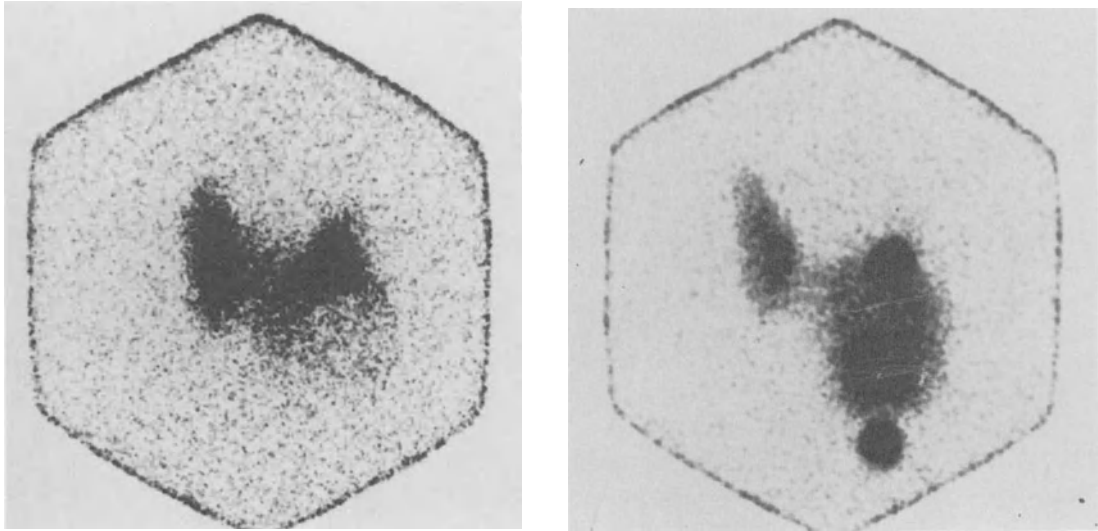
A normal thyroid scintigram made 3 hours after an oral dose of  $200\ \mu\text{Ci}^{123}\text{I}$ . The lobes are fairly symmetrical and the isthmus is not seen well.
